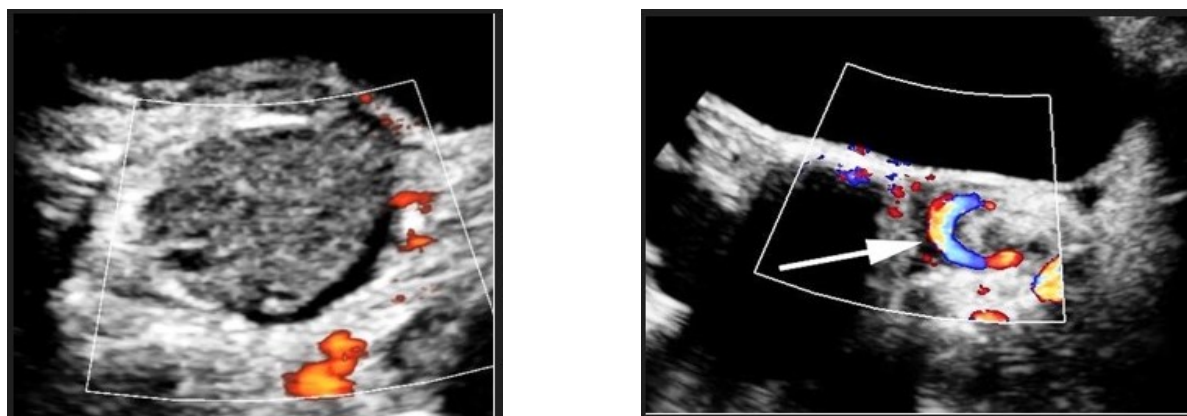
Dopplerography in case of adnexal torsion. (A) Absence of blood supply in the ovary; (B) "whirlpool" sign (arrow)
